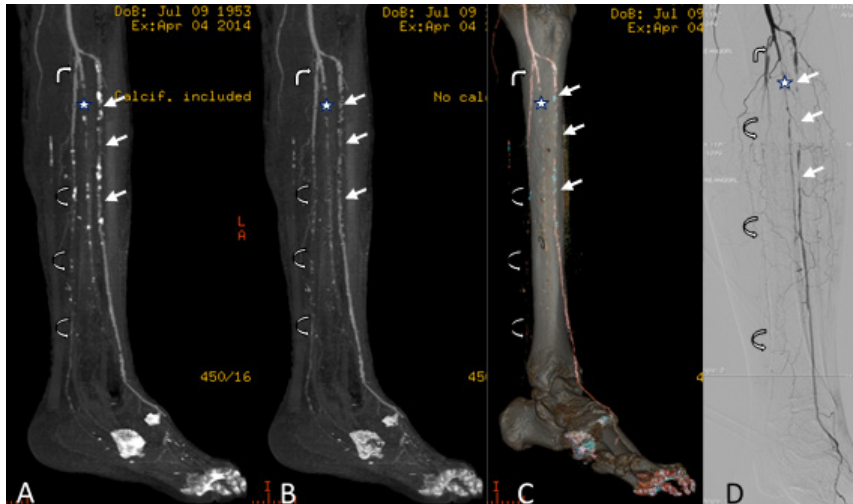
Comparison between CTA and DSA. A. 3D MIP with calcification included B. 3D MIP excluding calcification C. 3D volume rendering D. DSA. Note multiple occlusions of the anterior tibial artery in the proximal segment (straight arrows). Pathology is more severe with total occlusions on the peroneal artery (star) and posterior tibial artery (curved arrows). CTA also depicts a focal occlusion of the proximal segment of the posterior tibial artery (angled arrow).
